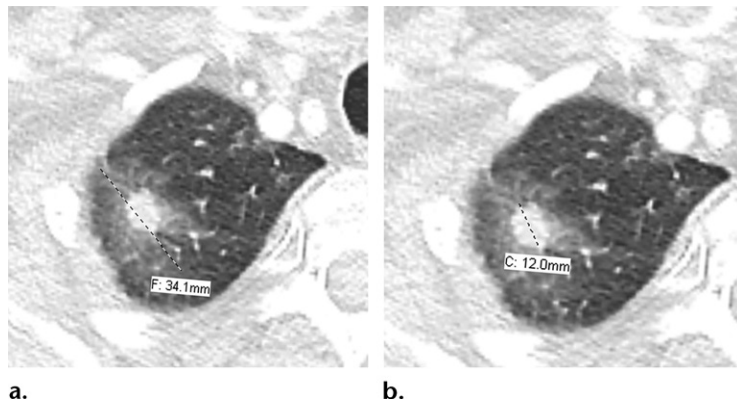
Measurement of part-solid lesions. Axial contrast-enhanced multidetector CT images of the right hemithorax of a 78-year-old woman show a part-solid nodule in the right upper lobe compatible with biopsy-proven invasive adenocarcinoma. (a) Image shows measurement of the entire lesion; the focal diameter (*F*) is 34.1 mm (dashed line). (b) Image shows measurement of the diameter of the solid component (*C* = 12.0 mm; dashed line). The IASLC recommends that the measurement of the solid component of part-solid lesions, representing the invasive component of the tumor, should be used to define its T classification. Investigators have demonstrated that this measurement better predicts prognosis than the overall tumor size in lepidic-predominant adenocarcinomas.
